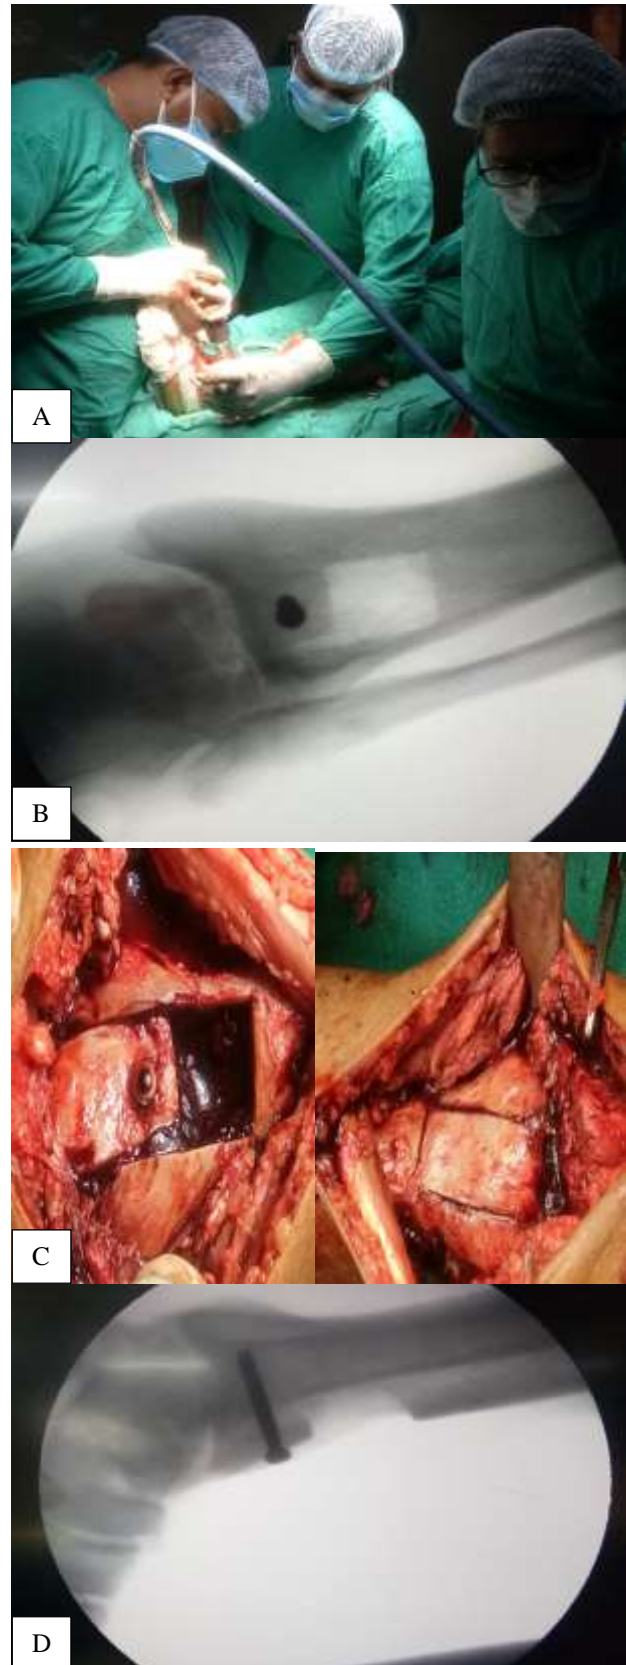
(A): Operating surgeon with team, (B) intraoperative C arm image of Blair procedure of ankle fusion, (C) intraoperative Blair procedure images, (D): x-ray images of ankle fused by Blair's procedure.
